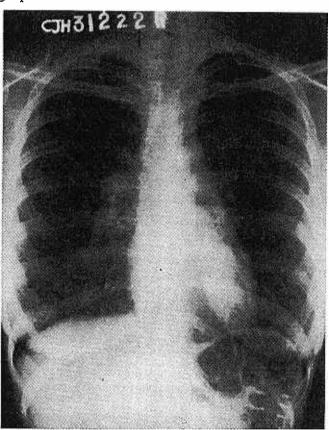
Chest radiograph (P—A view) of patient showing bilateral hilar lymphadenopathy. No parenchymal lesions are visible.
